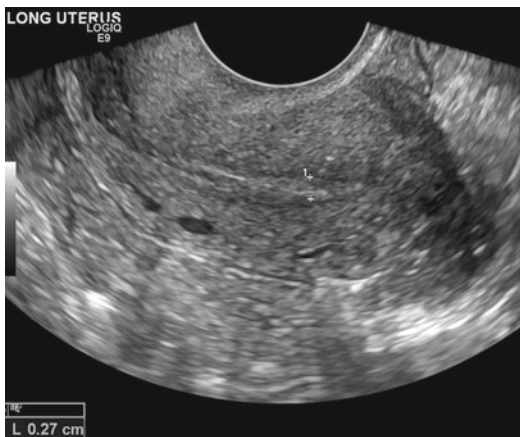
Sixty-five-year-old postmenopausal woman with abnormal bleeding. Sagittal endovaginal sonogram demonstrated a thin 3 mm endometrium suggestive of endometrial atrophy
